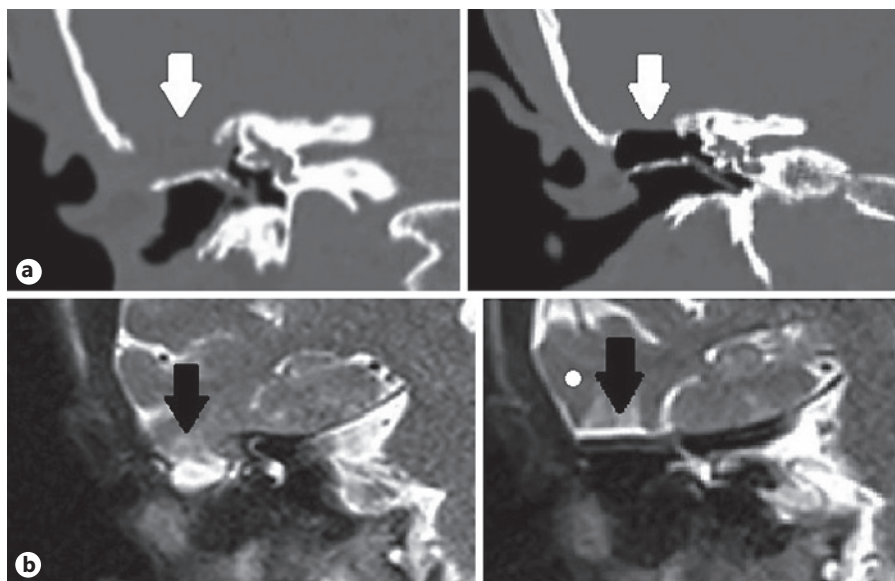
a Pre- and postoperative radiological findings of the patient no. 1. Preoperative and postoperative computerized tomography coronal view (white arrow: 16-mm TD). b Pre- and postoperative magnetic resonance imaging coronal T2 sequences (black arrow: MEH). TD, tegmen defect; MEH, meningoencephalic herniation.
